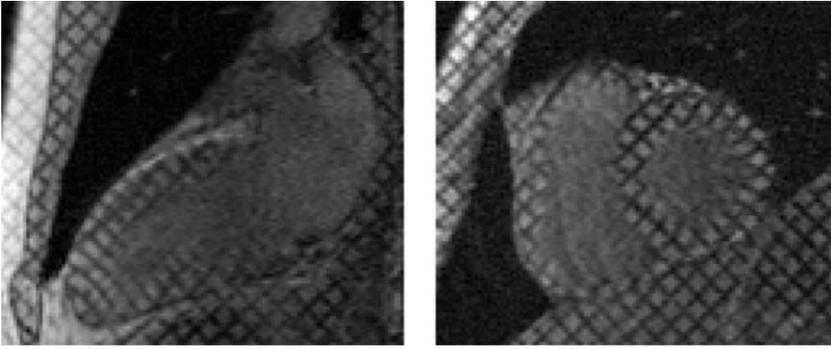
Long axis (*left*) and short axis (*right*) tagged-MR images of the heart. Images courtesy of Clínica Creu Blanca (Barcelona, Spain).
